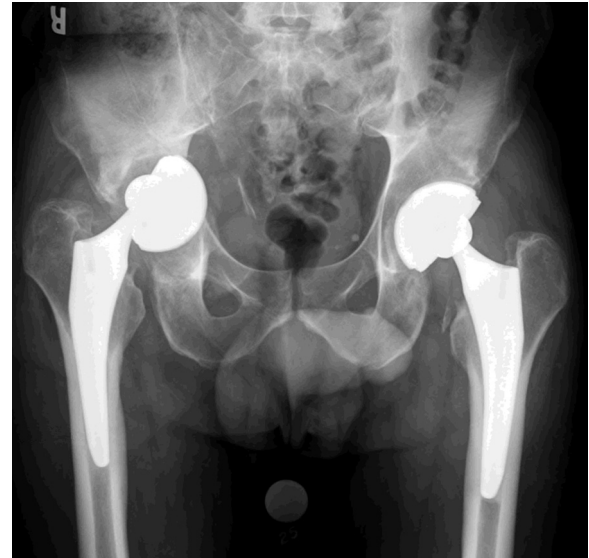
Anteroposterior (AP) radiograph of case 3 at presentation with dual mobility right THA demonstrating acetabular loosening with migration and bone loss.
